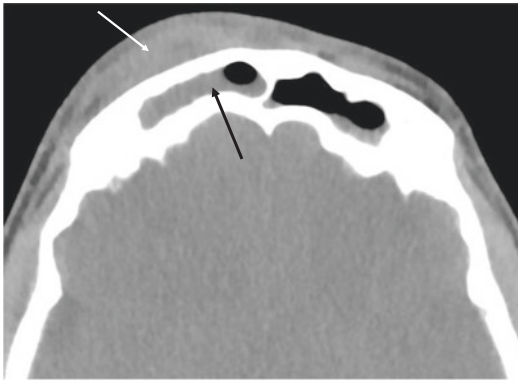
Non-contrast axial CT of the head showing bubbly secretions in the right frontal sinus (black arrow). There is fluid, subcutaneous swelling, and fat stranding anterior to the right frontal sinus in keeping with a developing subgaleal abscess with overlying cellulitis (white arrow)
